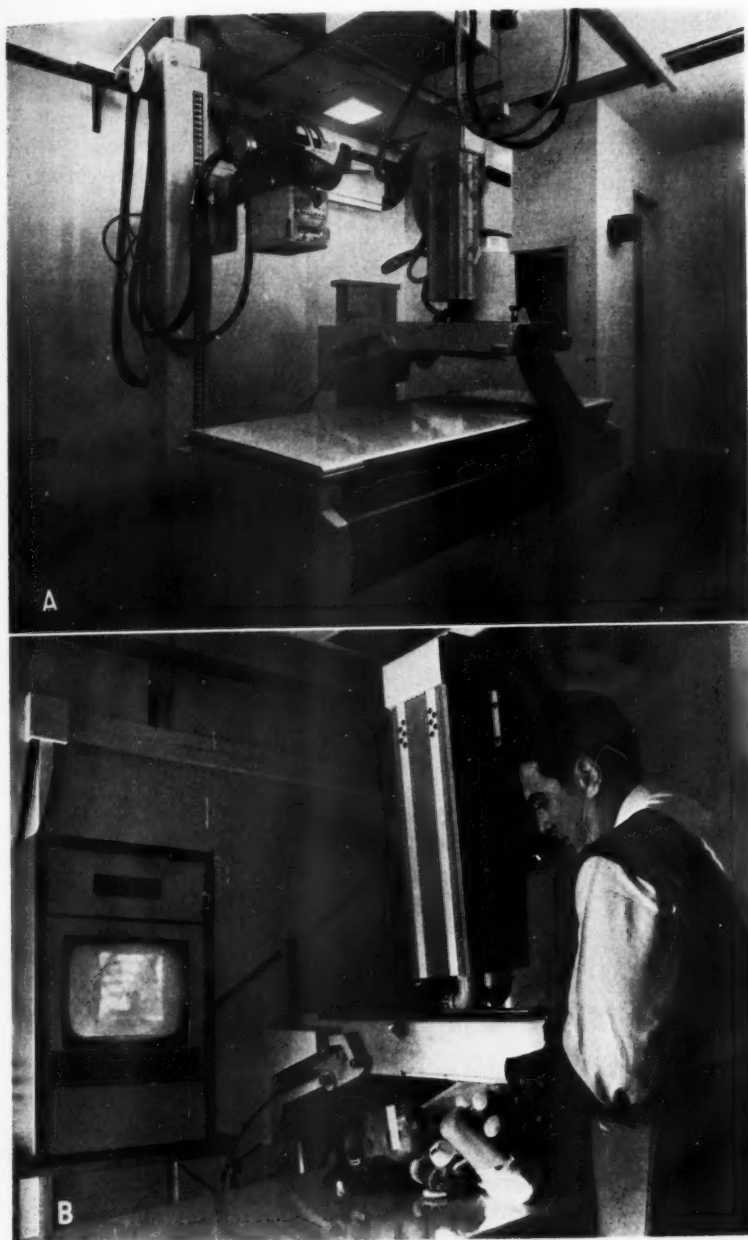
A. An x-ray fluoroscopic room at the Children's Hospital of Pittsburgh containing the Teleflex unit.
